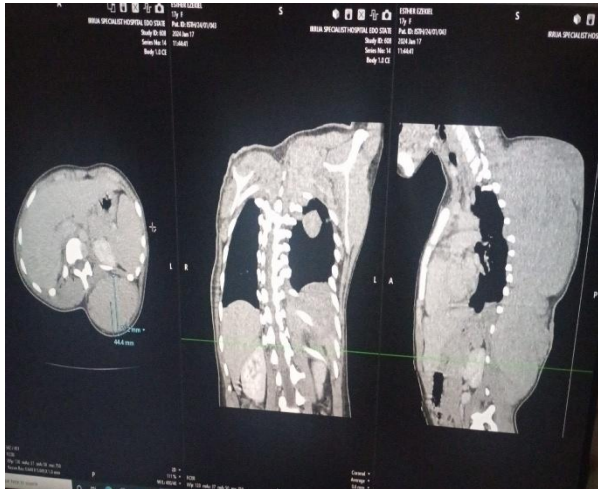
above images showed the chest computed tomography before surgery. In case B
